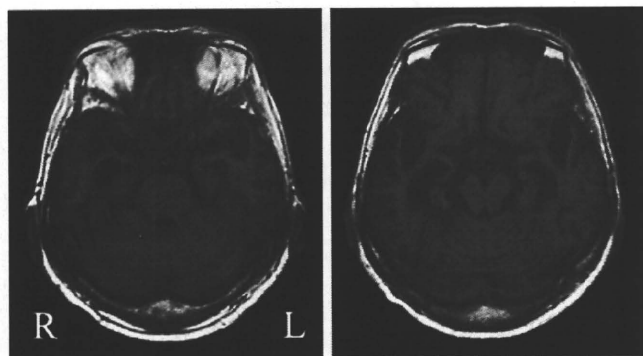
T1-weighted magnetic resonance images show severe atrophy in the anterior temporal lobes at the early clinical stage.
